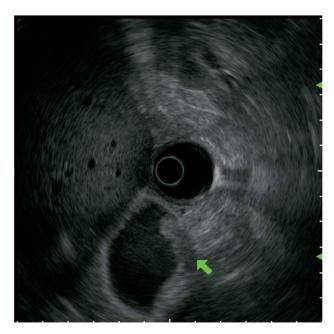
Endoscopic ultrasonography revealed a high-echoic elevated lesion in the gallbladder neck and tumor infiltration as a hypoechoic tumor invading the layers of the gallbladder wall (arrow).
